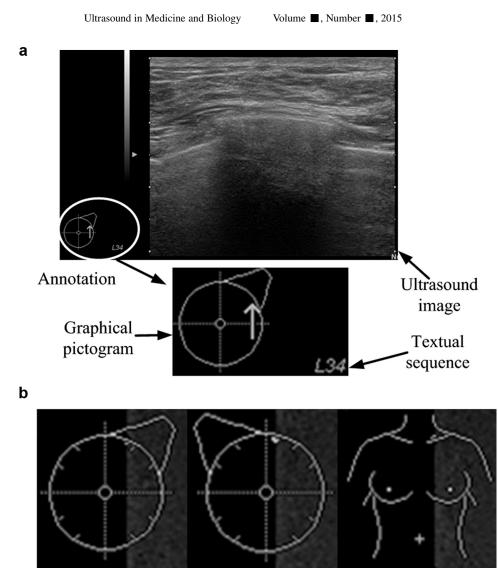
Typical ultrasound display in breast examination. (a) Typical annotation components including the graphic pictogram and textual sequence. (b) Three common types of graphic pictogram.
